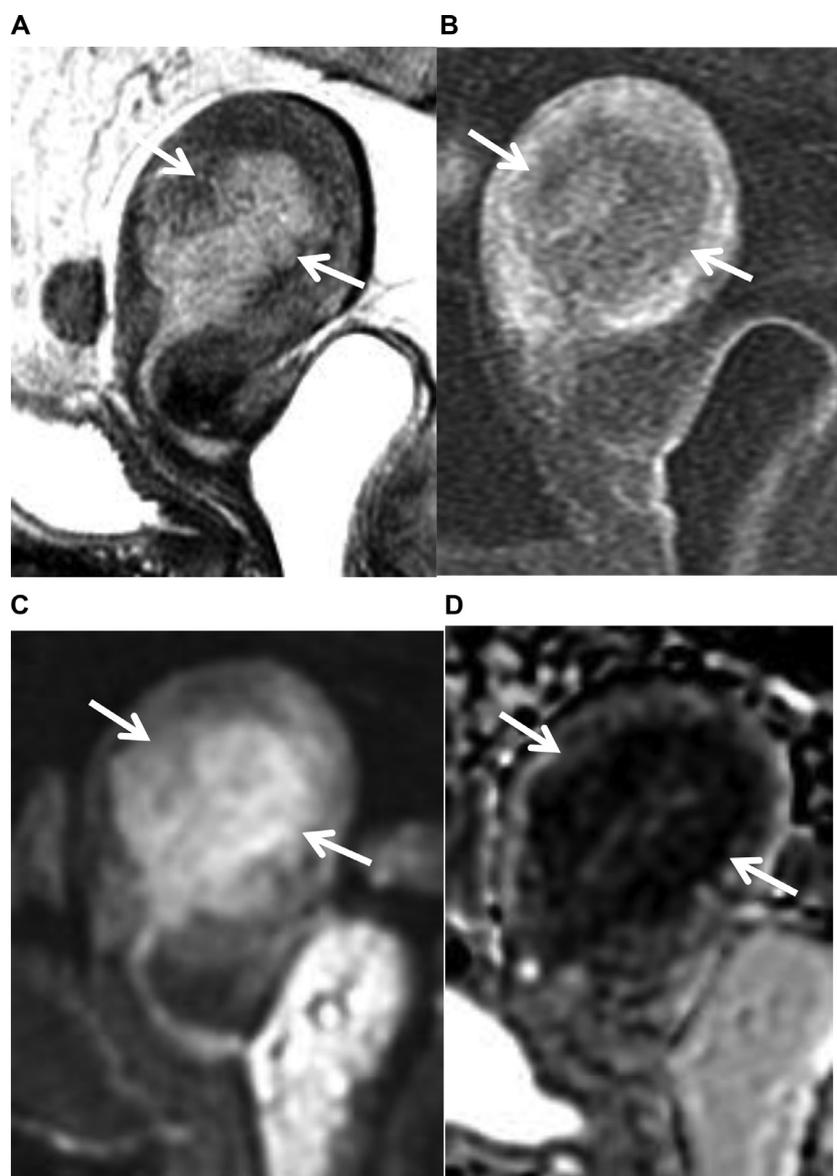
65-year-old female with endometrial cancer. (A) Sagittal T2-weighted, sagittal postcontrast T1-weighted image (B), (C) DWI and ADC map (D) images show a large irregular mass (arrows) distending the endometrial cavity with more than 50% myometrial invasion. It is a Stage IB endometrial cancer with more than 50% myometrial invasion.
